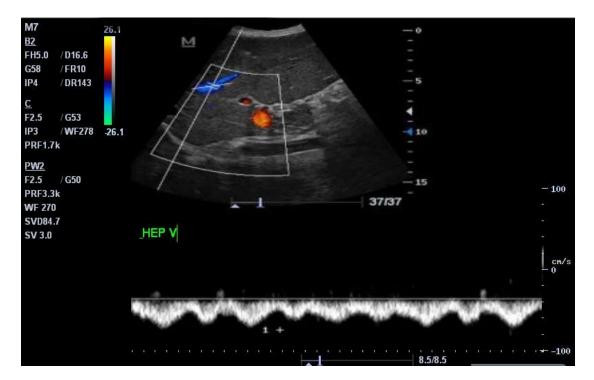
31 year old male. Doppler ultrasound of the middle hepatic vein demonstrates biphasic waveform
